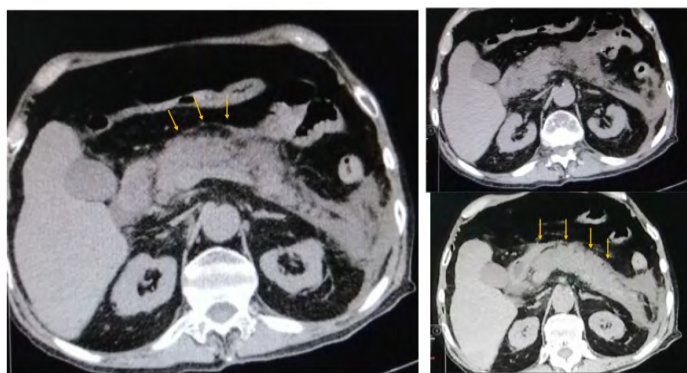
Computed Tomography Scan: Edematous pancreatitis with peripancreatic inflammation, peripancreatic fluid in all peritoneal recesses. Baltazar C.
